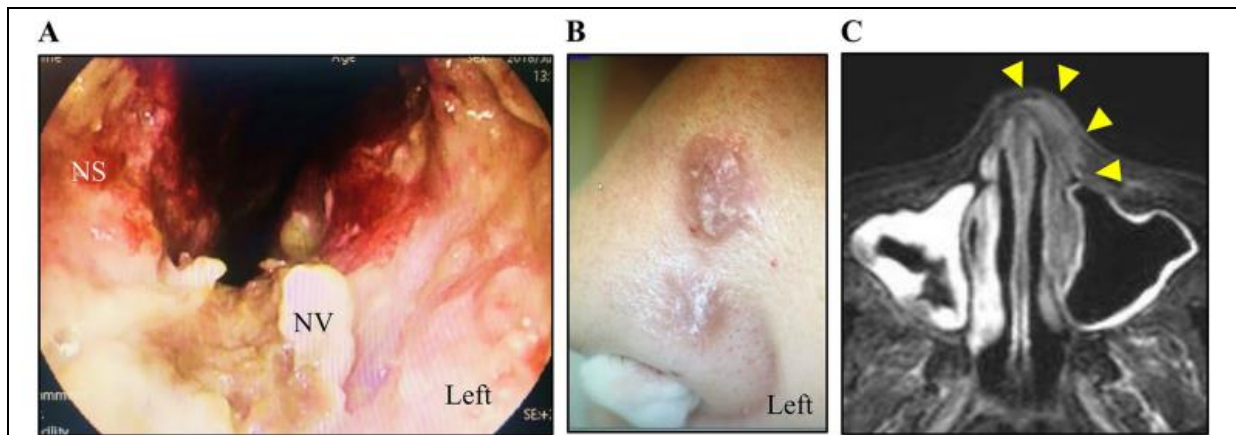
(A) Erosions in nasal cavity; (B) Rash on the left dorsum of nose; (C) MRI findings showing inflammation.
